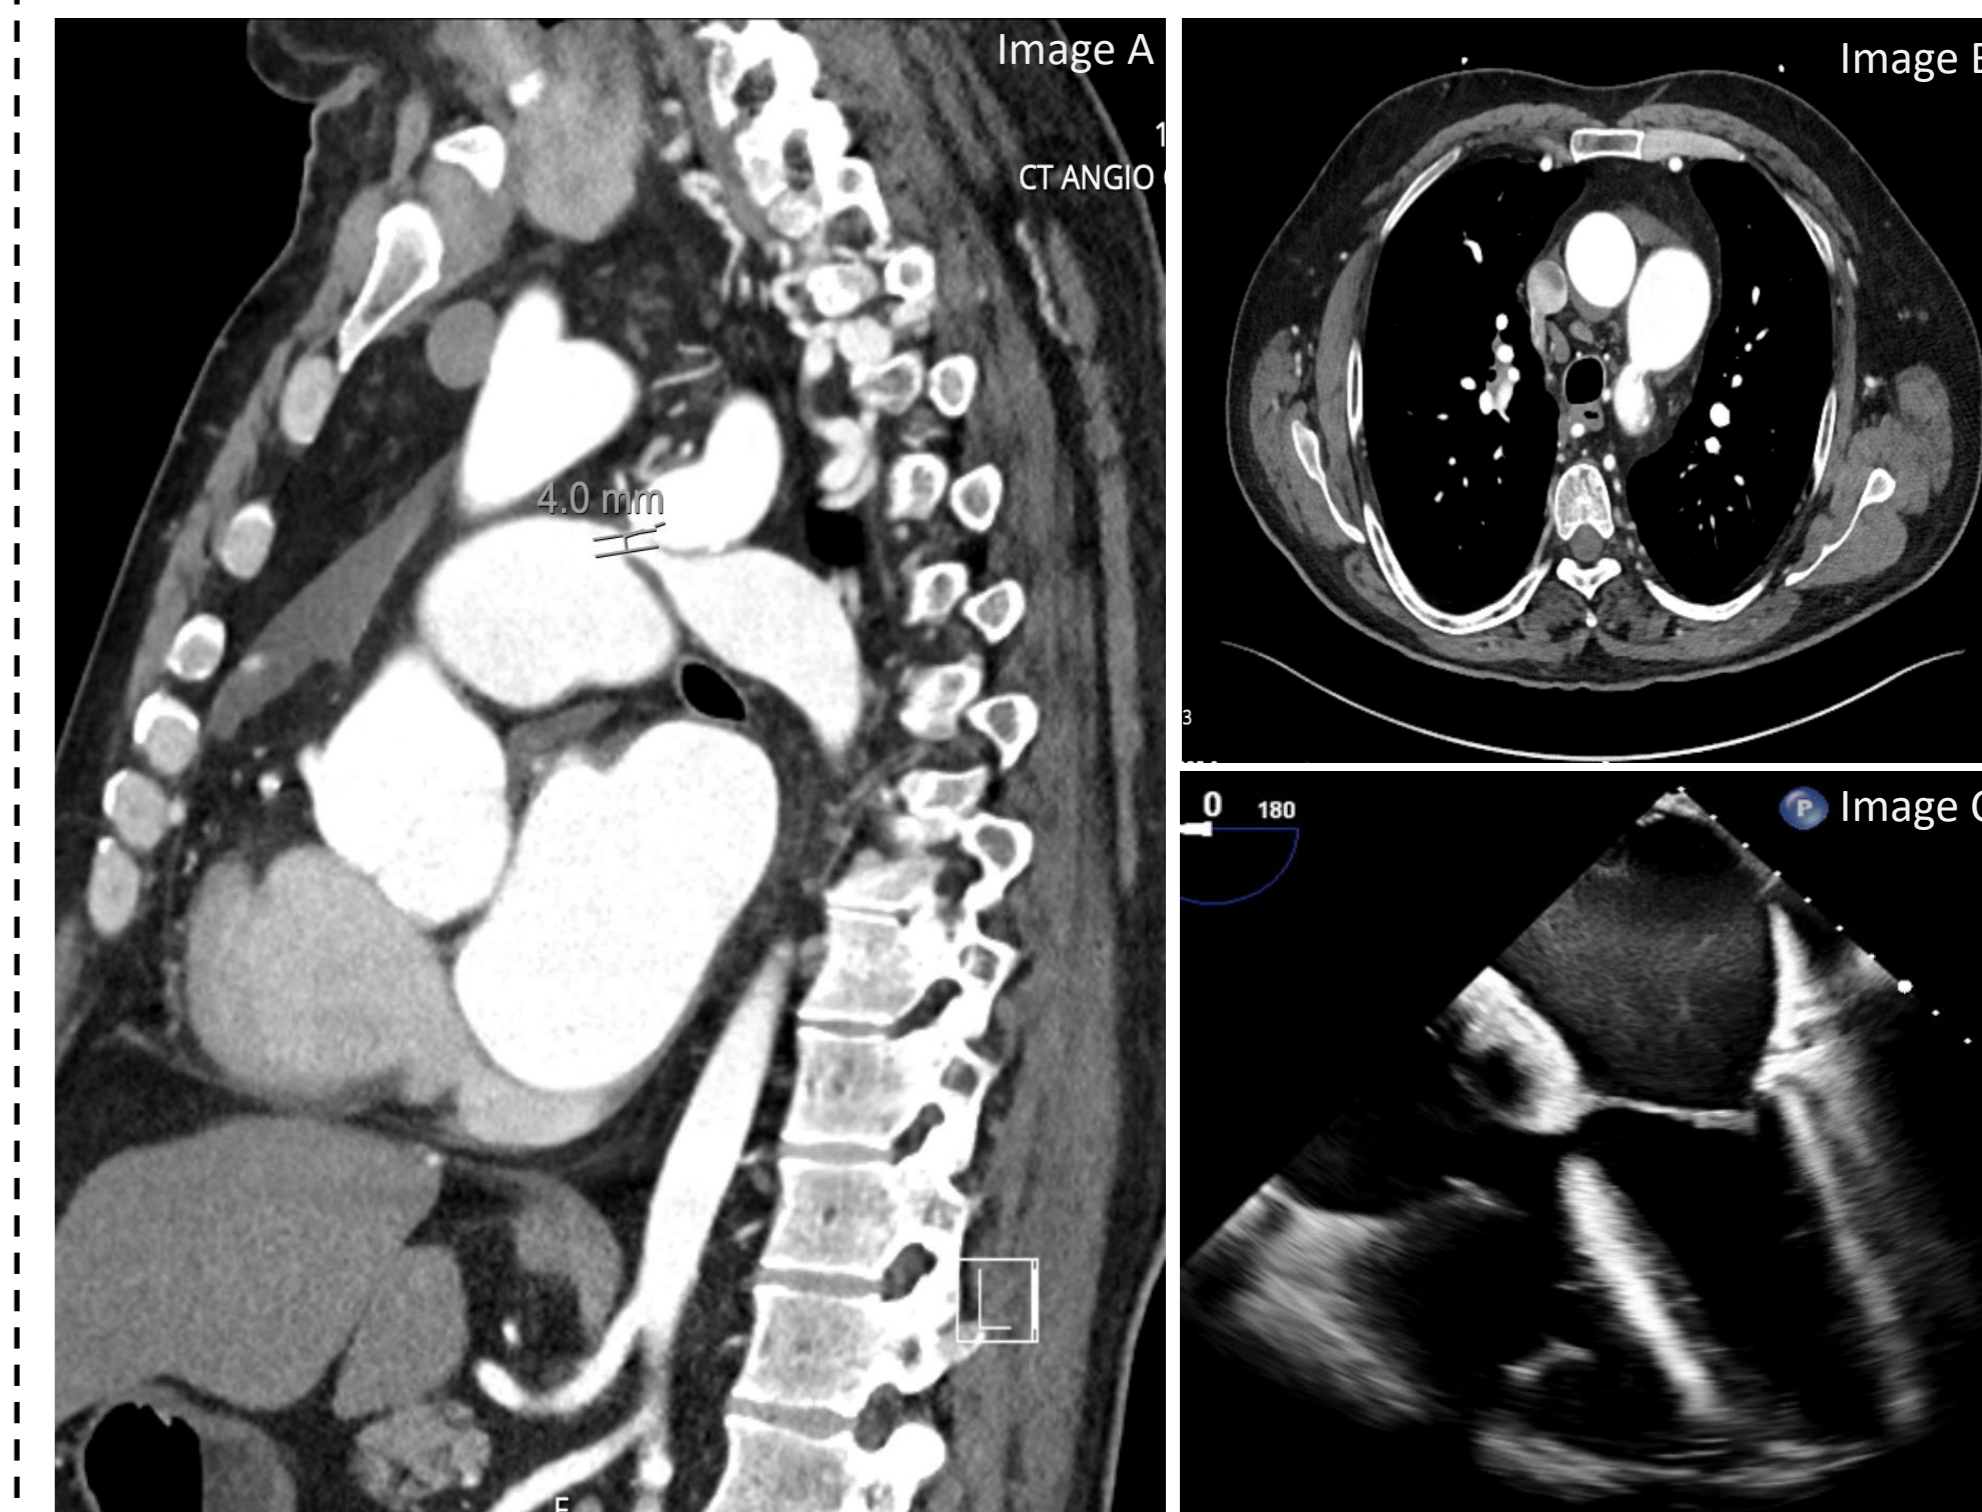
Sagittal CT scan shows the PDA measurement as the aorta pinches down to the CoA and connects to the left pulmonary artery (PA)
